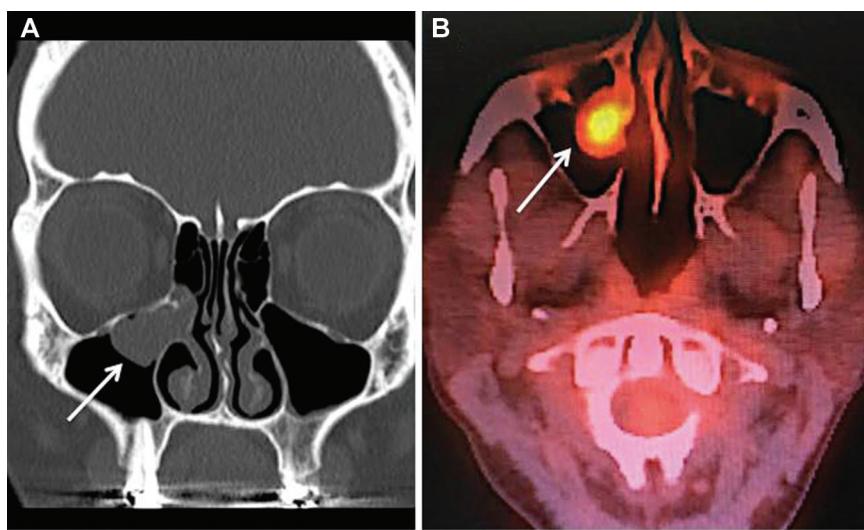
(A) Preoperative coronal computed tomography paranasal sinuses and (B) axial positron emission tomography–computed tomography demonstrating a single enhancing mass isolated to the right maxillary sinus antrum (arrows) with no radiologically identifiable extension into skull base.
